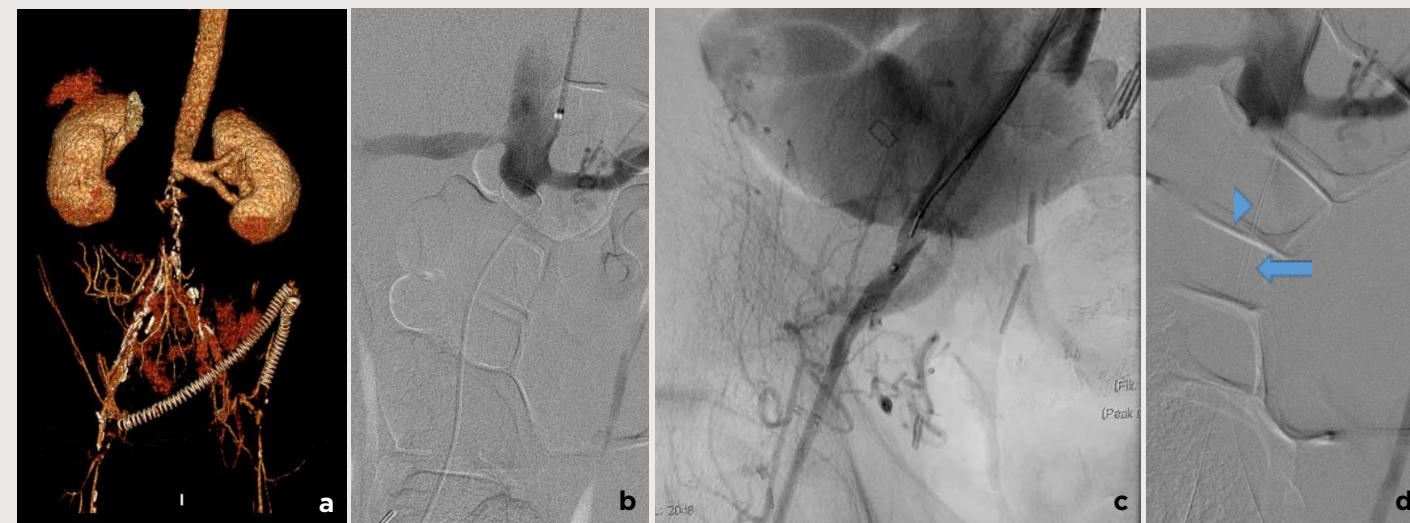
CT angiogram 3D reconstruction of juxta renal aortic occlusion (a). DSA obtained via long sheath from left brachial artery access (b). A through-and-through wire established via antegrade approach from brachial access. Similarly, this was performed on contralateral side (c). Blue arrows depict the bilateral, endoluminal wire access to proximal aorta prior to angioplasty and stent deployment (d). DSA demonstrated successful Viabahn (W.L. Gore & Associates Inc., Flagstaff, Arizona) deployment across long, TASC II D aortoiliac occlusion (e).
